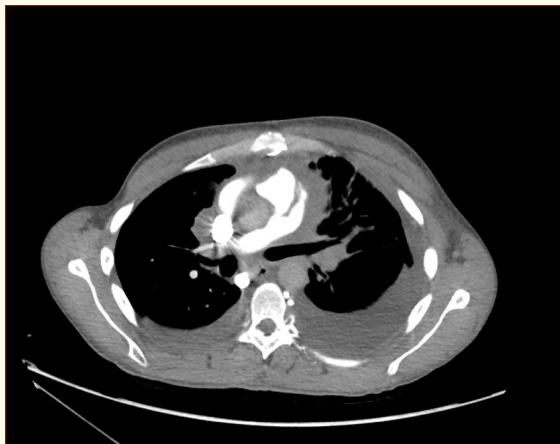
CT chest was done post-surgery confirmed patency of the conduit.
